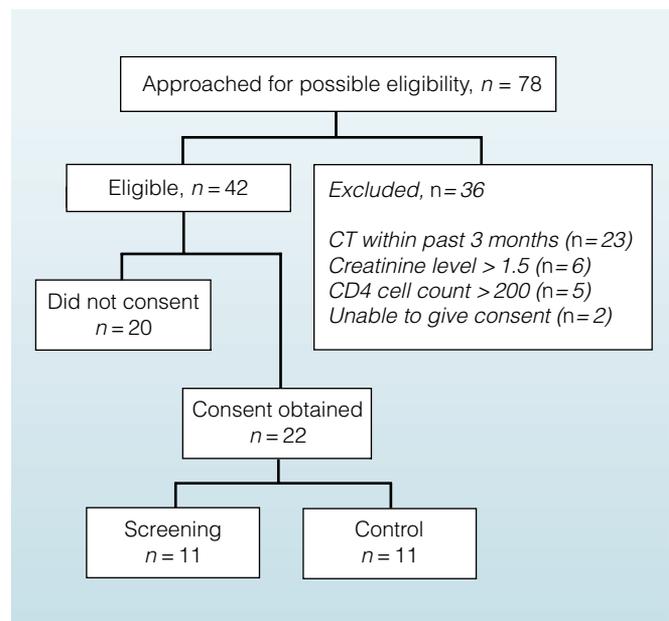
Patient selection process and inclusion–exclusion criteria. CT = computed tomography.
